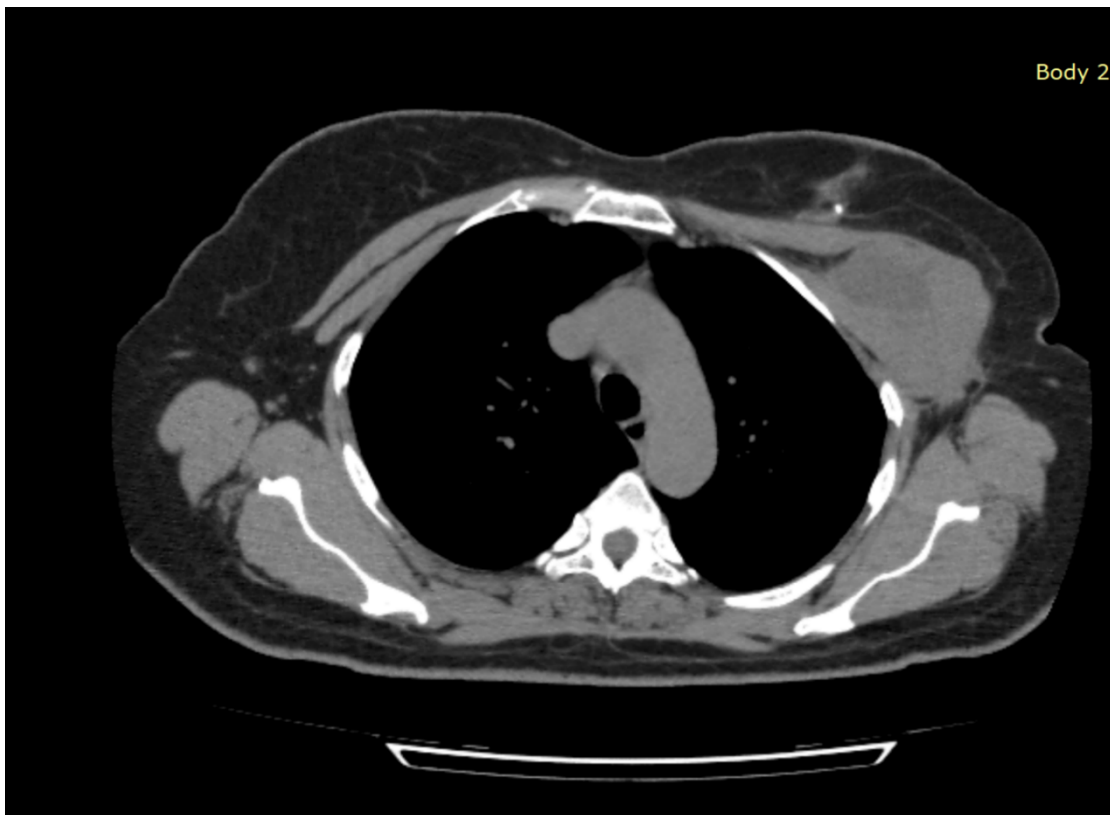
CT scan showing left chest wall lesion involving pectoralis muscles, Intact intercostal muscles
